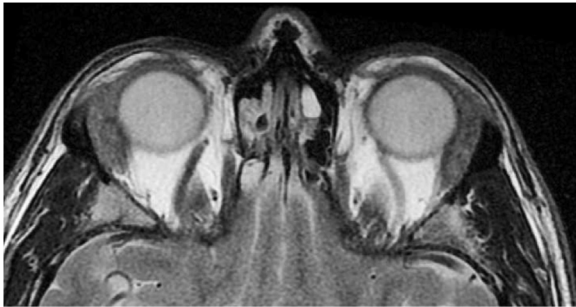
Magnetic resonance imaging of the orbits with contrast material: bilateral fat-suppressed T₂ sequence with lacrimal gland enlargement and normal enhancement.
